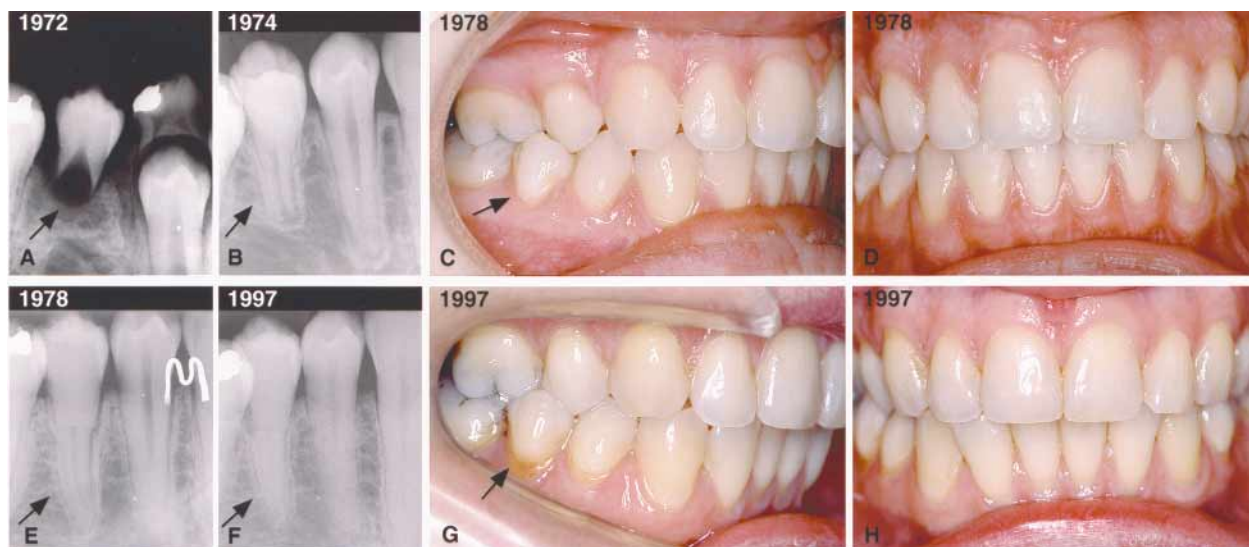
Because of agenesis of mandibular right second premolar in 12-year-old girl, maxillary second premolar in same side was transplanted to mandible in 1972 (arrow in A). Root development continued (arrow in B), and eventually root achieved similar length as that of neighboring first premolar (E). Intraoral photographs show result in 1978 (C, D) and 19 years later (G, H) with buccal crossbite of graft (C). Note normal radiographic appearance, albeit with some continuation of pulp obliteration (compare F with E).
